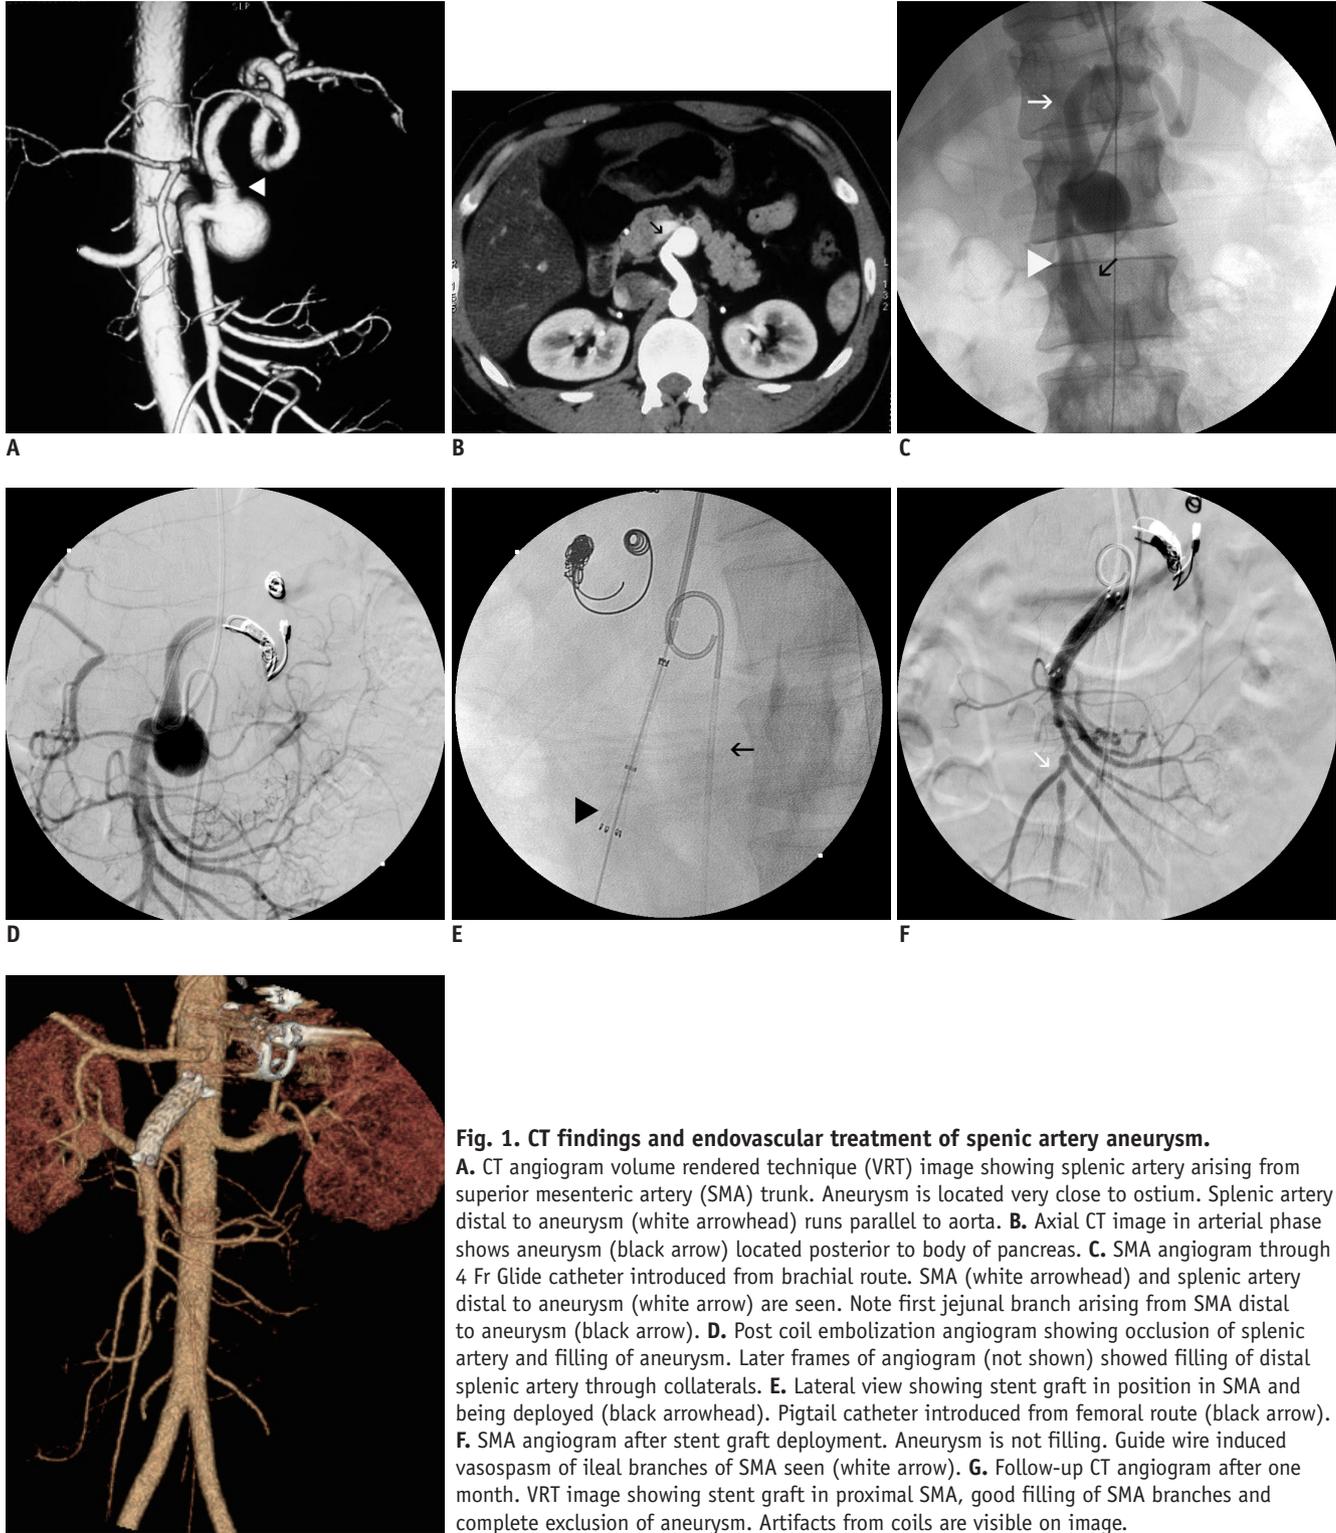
CT findings and endovascular treatment of splenic artery aneurysm.
